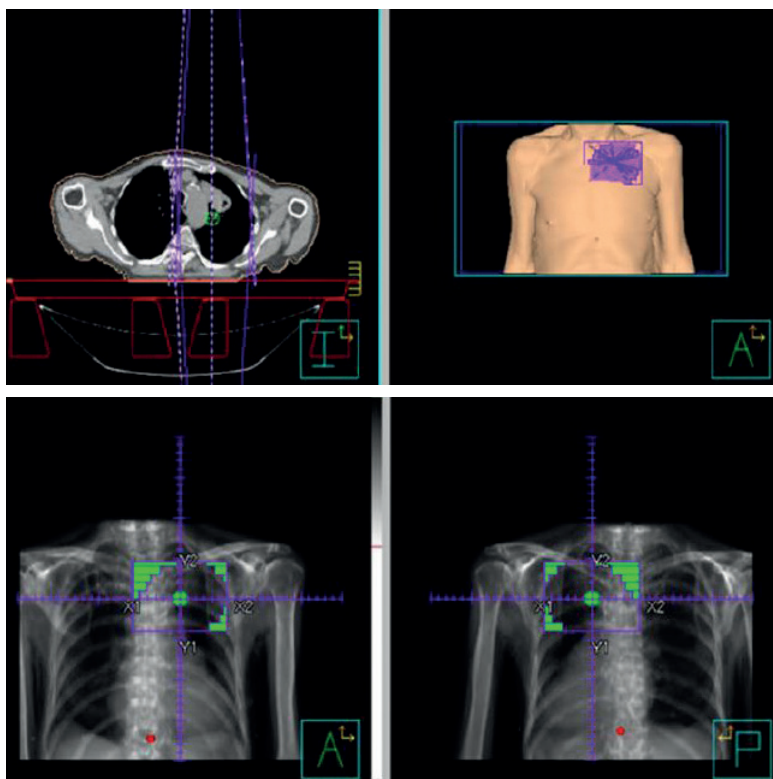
The same case showing: (a) the beam setup, (b) two (anterior and posterior) beams are assigned to this prescription; surface rendered view of the radiotherapy field. Inferiorly, (c) anterior and (d) posterior beam's eye view digitally reconstructed radiograph.
